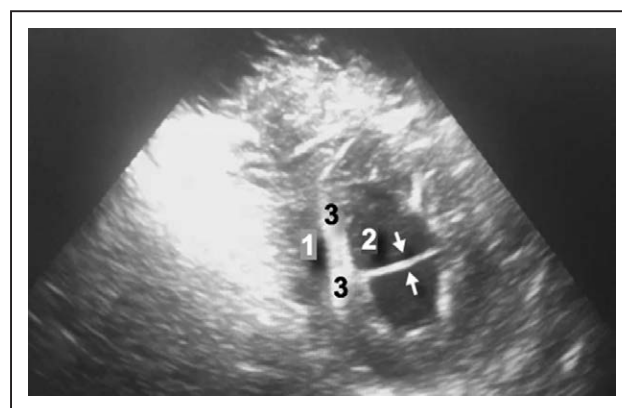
Intracardiac ultrasound with left ventricle false tendon closely related with high-voltage apicoseptal region shown on 3-dimensional mapping.
